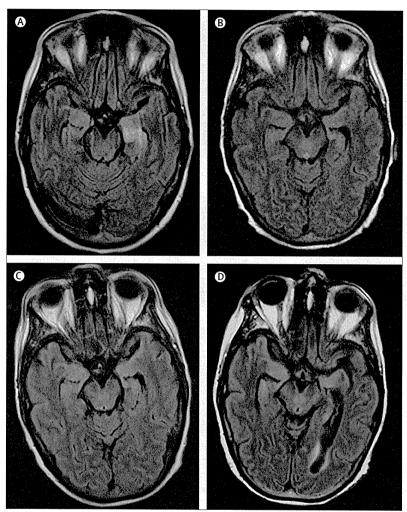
MRI of a patient with GABA_B receptor antibodies and limbic encephalitis
